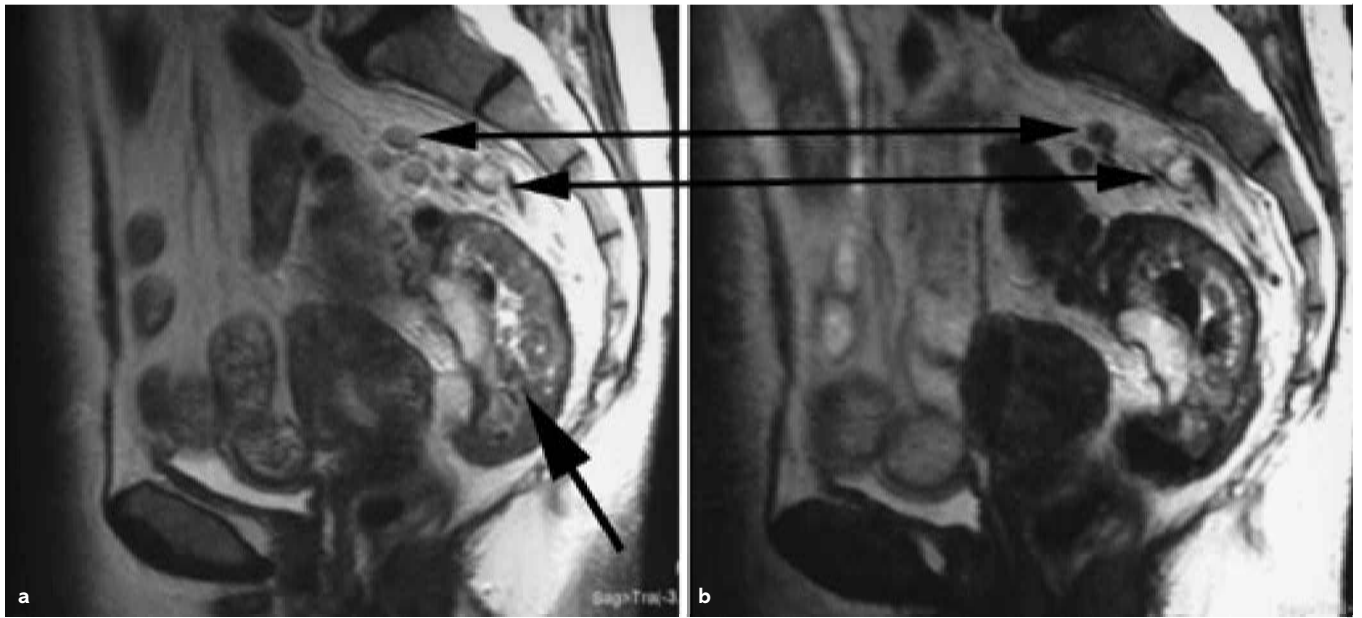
Magnetic resonance imaging (MRI) lymphography: (a) sagittal MRI image of the pelvis showing a large mid-rectal tumour (arrow) and enlarged presacral lymph nodes (arrows); (b) similar image acquired 24 hours after intravenous administration of ultrasmall super-paramagnetic iron oxide particles. All but one of the lymph nodes have decreased in signal intensity (see corresponding arrows). The lymph node showing no change in signal intensity (lower arrow) was replaced by metastatic disease. All other lymph nodes were benign at pathology (reproduced courtesy of Mr S Rasheed, Northwick Park and St Mark's Hospital).
